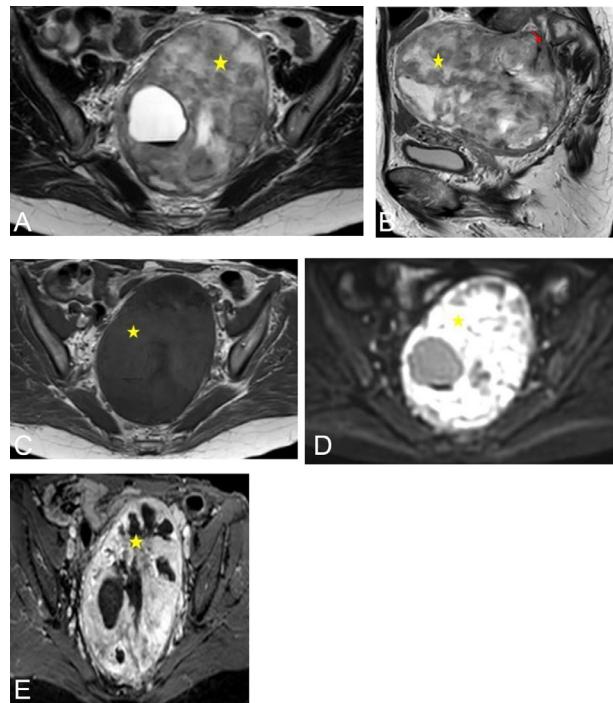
Injected pelvic MRI showing a voluminous retroperitoneal mass (★), well encapsulated, occupying the sacral concavity, in T1 iso signal (A), in T2 heterogeneous signal (B and C), with a fluid portion in hypersignal and a tissue portion in intermediate signal which appears to impinge on the left first sacral foramen (red arrow), restrictive to diffusion (D) and heterogeneously enhanced after injection of Gado (E).
